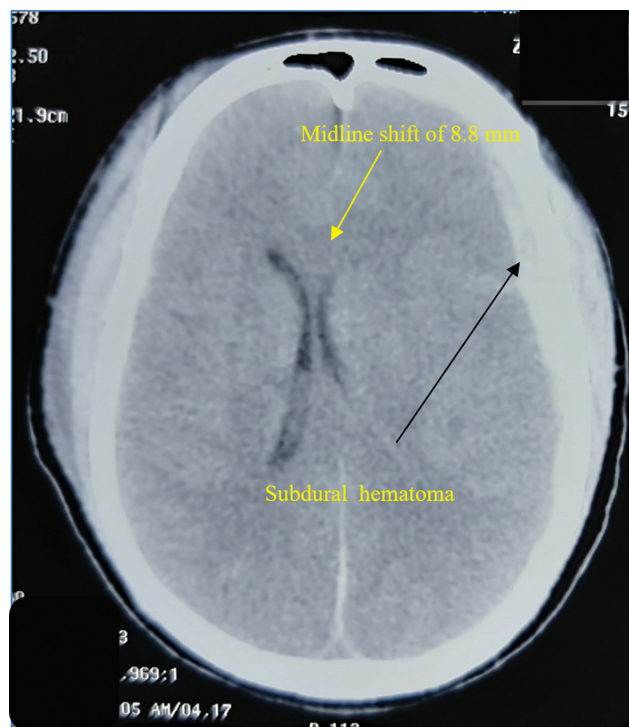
Noncontrast computed tomography head at the day of admission.
